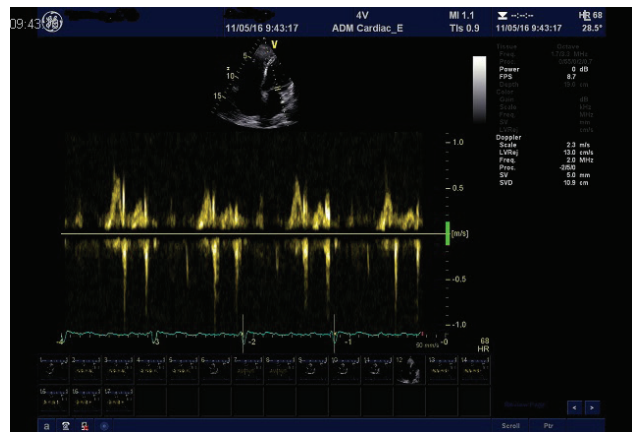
Pulsed wave Doppler over the mitral valve. This demonstrates normal sinus rhythm
